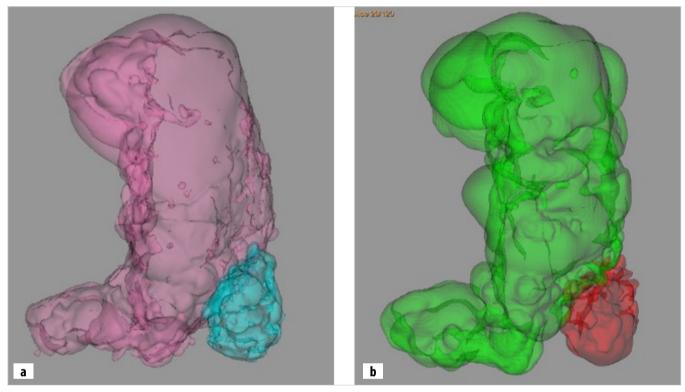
Computed tomography scans before (a) and after (b) the introduction of BTA with 3D modeling of the volumes of the hernial sac and abdominal cavity.
